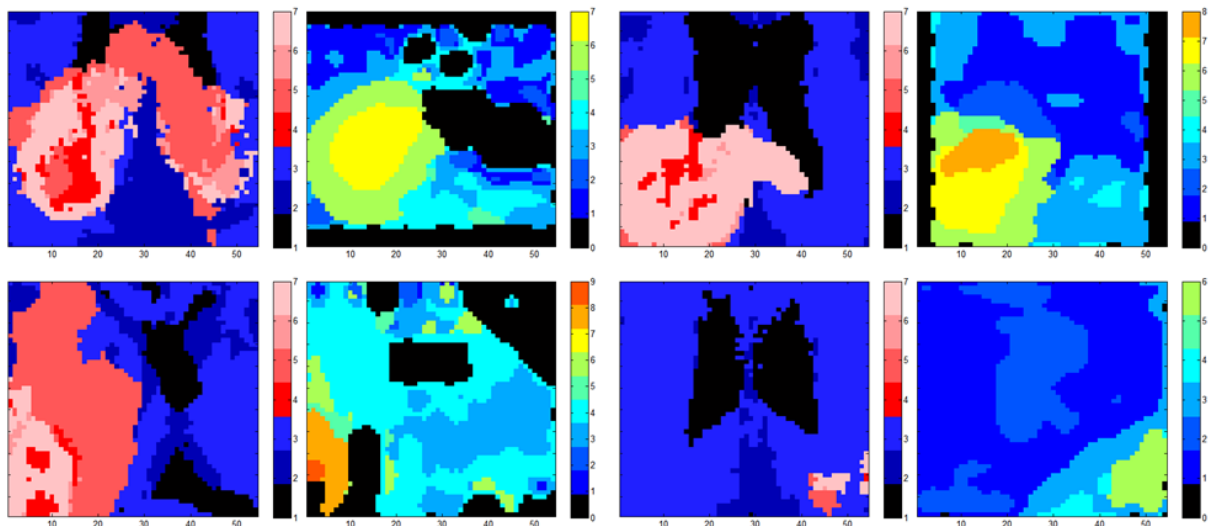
Comparison between the MRI and MRSI segmentations for 4 of the cases included in the test-set. MRI segmentation performed using BratumIA.
